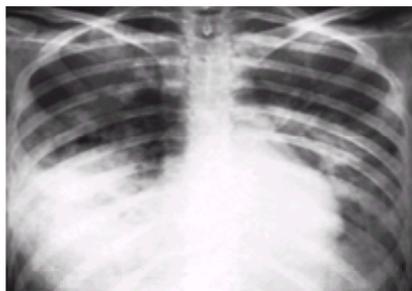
Chest roentgenogram of a 21-year-old woman with combined staphylococcal and influenza virus pneumonia. (Reproduced with copyright permission of The American Society for Clinical Investigation from Louria DB, et al. Studies on influenza in the pandemic of 1957–1958: II. Pulmonary complications of influenza. *J Clin Invest* 1959;38:213.)
